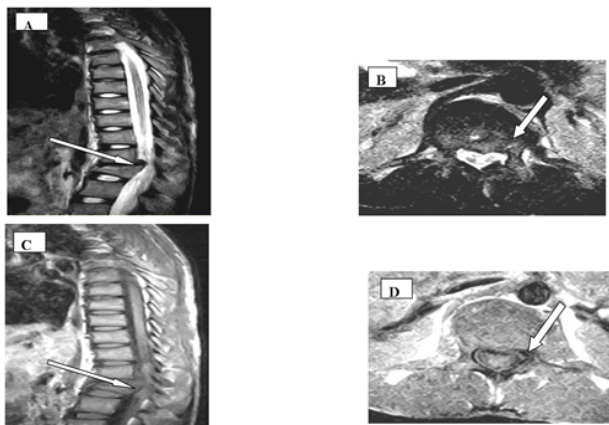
53-years-old woman admitted with post traumatic tetraplegia. Dorsal spine MRI T2 weighted sagittal (A) and (B) axial sequences; T1 weighted with sagittal (C) and axial (D) showed a wedge-shaped settlement of T12-L1 to posterior wall recoil with compression of the terminal cone that evocated a post trauma sequels.
